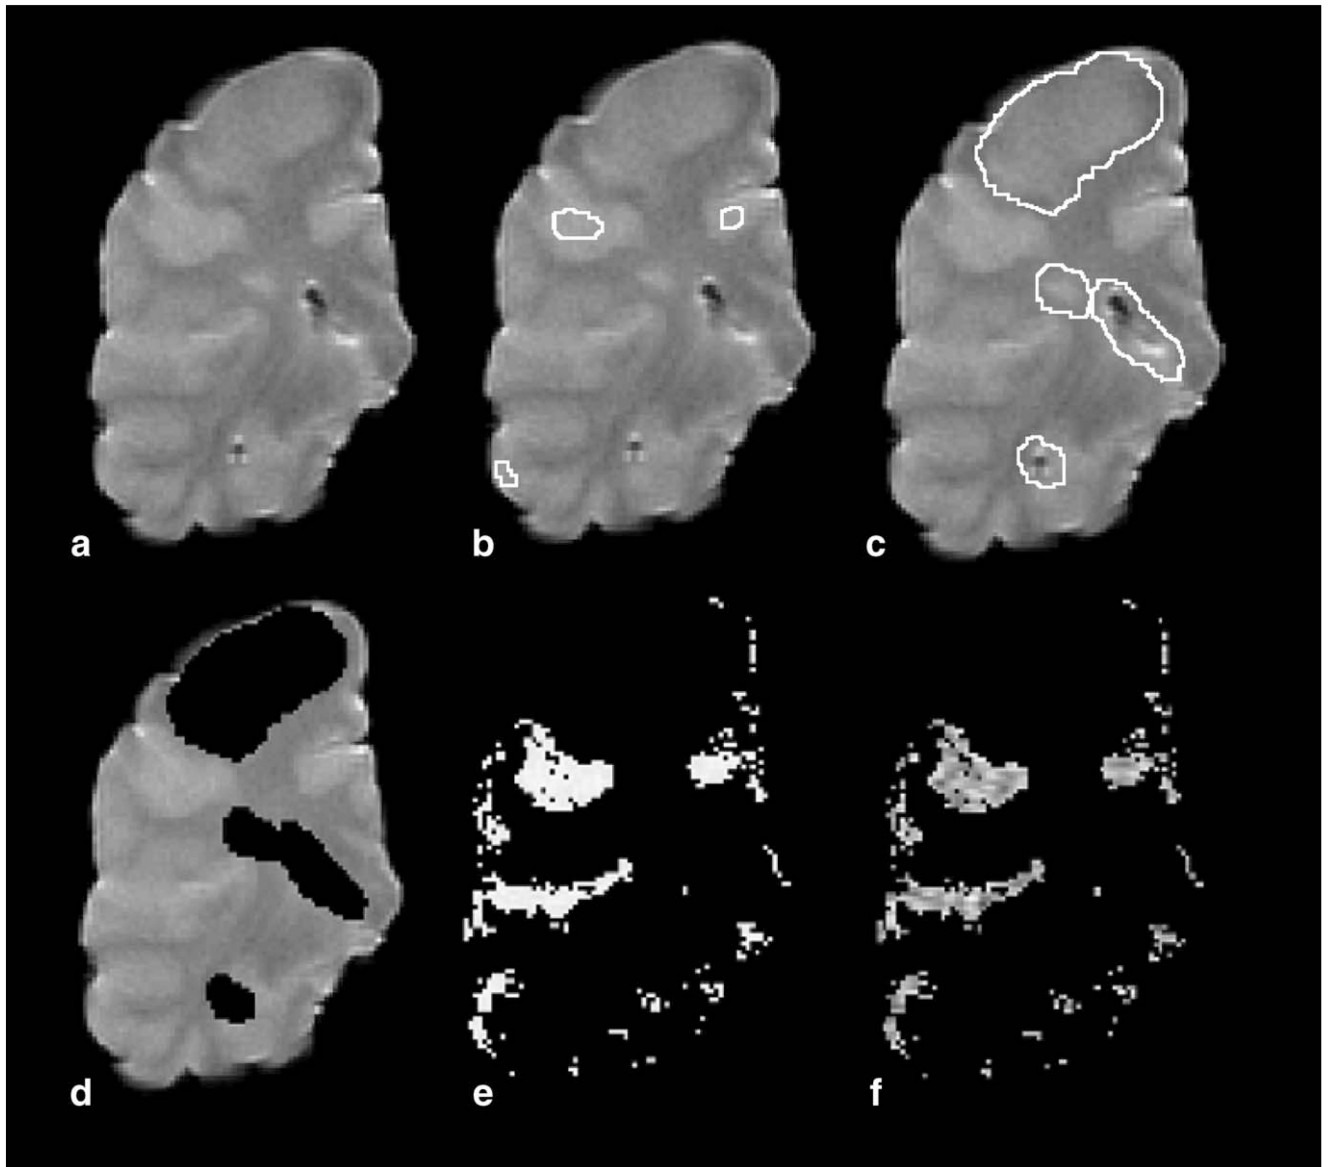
Processing of magnetic resonance images for production of CGM masks.
